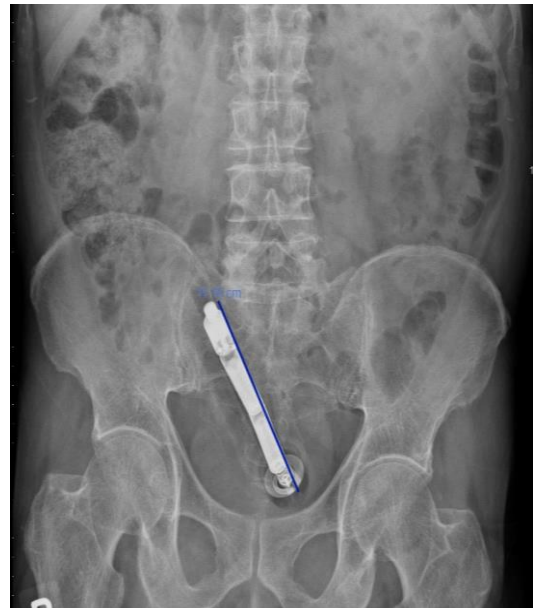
Abdominal radiograph showing an 11 cm radiopaque prostate massager in the pelvis.
